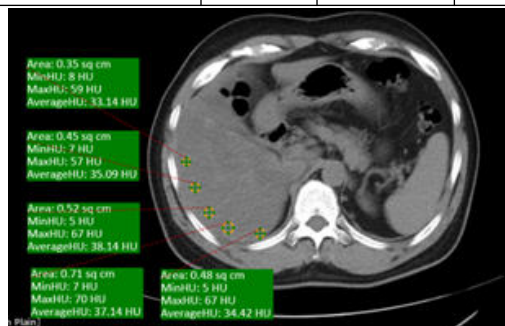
Plain CT axial image shows that the average HU values of the liver were falling below 40 HU.
